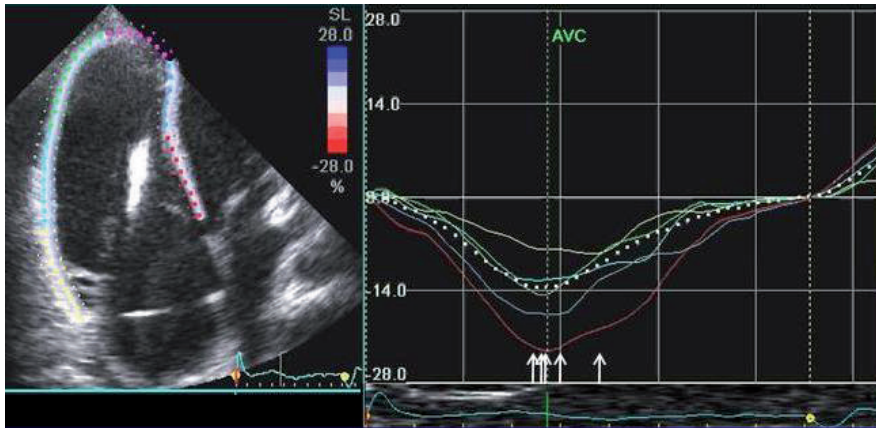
Longitudinal (left panel) and circumferential (right panel) strain in a symptomatic LQTS patient by speckle tracking echocardiography. Longitudinal strain mainly measures subendocardial myofibers, while circumferential strain mainly measures mid-myocardial fibers. Mean longitudinal strain was longer compared to mean circumferential strain in this symptomatic LQTS patient, indicating transmural mechanical dispersion.*
